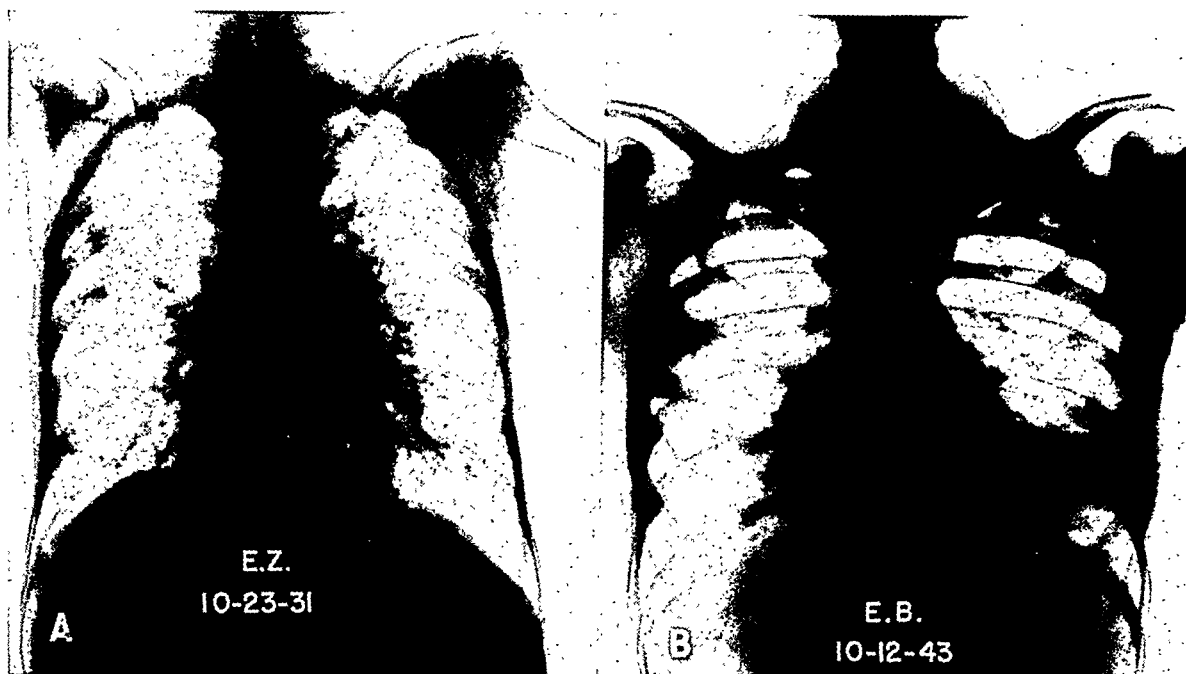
Cases 10 and 11. Extensive confluent and submiliary infiltrations in diffuse sarcoidosis. In these cases, it is impossible from the roentgen appearance to determine whether other disease, such as tuberculosis or bronchiectasis, is present.
